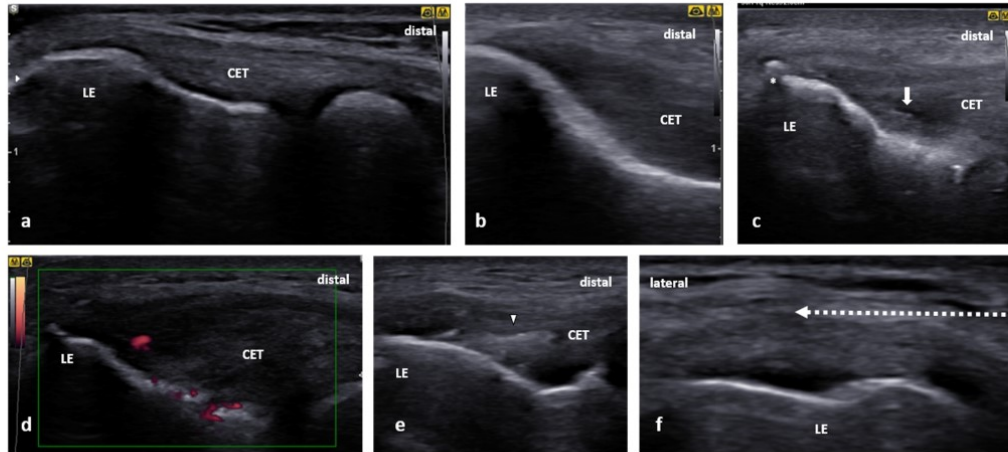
Ultrasound (US) images of the CET: (a) normal image, (b) a simple thickening and hypoechogenicity of the CET, (c) US image demonstrating a prominent spur (white asterisk) on the tip of the lateral epicondyle (LE) and focal hypoechogenicity in the tendon (white arrow), (d) a severe swelling of the CET with increased vascularity on power Doppler, (e) a mild swelling of the CET with intrasubstance hyperechogenicity indicating an immature calcification (white arrowhead) without acoustic shadowing, and (f) a US-guided peritendinous CET injection showing the needle (white, dotted arrow) being inserted from medial to lateral in a short axis of the CET.
